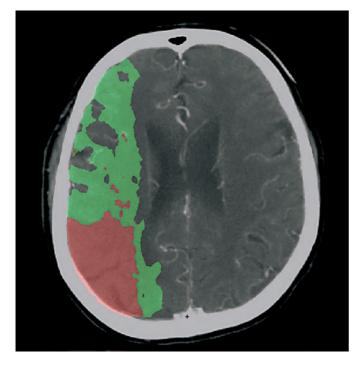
This perfusion CT shows a large region with reduced CBF without a collapse of CBV (green region) and a relatively small region with both reduced CBF and CBV collapse (red region). Dr. Julien Bogousslavsky, Lausanne, Switzerland, supplied the figure.
